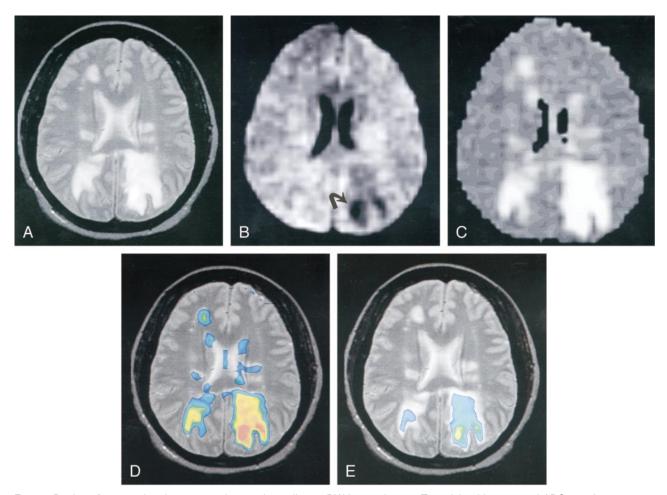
Region of vasogenic edema appearing much smaller on DW image than on T2-weighted images and ADC map in a 28-year-old woman with PRES resulting from severe hypertension. This case shows that lesions with decreased SI on DW images have higher ADC values than lesions that have normal SI on such images. As a result, the contribution of T2 effects in these lesions is not sufficient to cancel the decreased SI caused by elevation of ADC values, and T2 washout does not occur.
